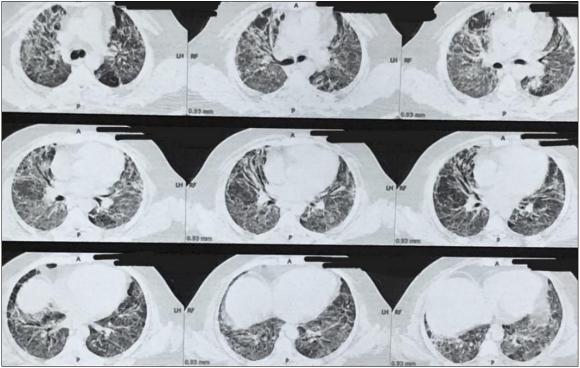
HRCT thorax showing Persistent residual radiological lung abnormalities (PRLAs) all lobes with reticulations and fibrotic bands in middle and lower lobes done at one year follow-up
